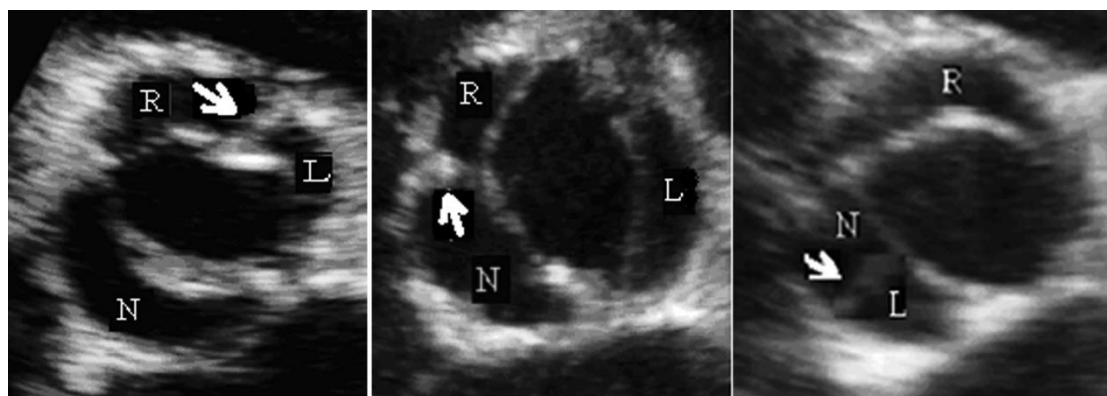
Echocardiographic view of three different phenotypes of Bicuspid Aortic Valve (BAV). R-L form: the right and left cusps are connected by a raphe (arrow). R-N form: the right and non-coronary cusps are connected by a raphe (arrow). N-L form: the non-coronary and left cusps are connected by a raphe (arrow).
